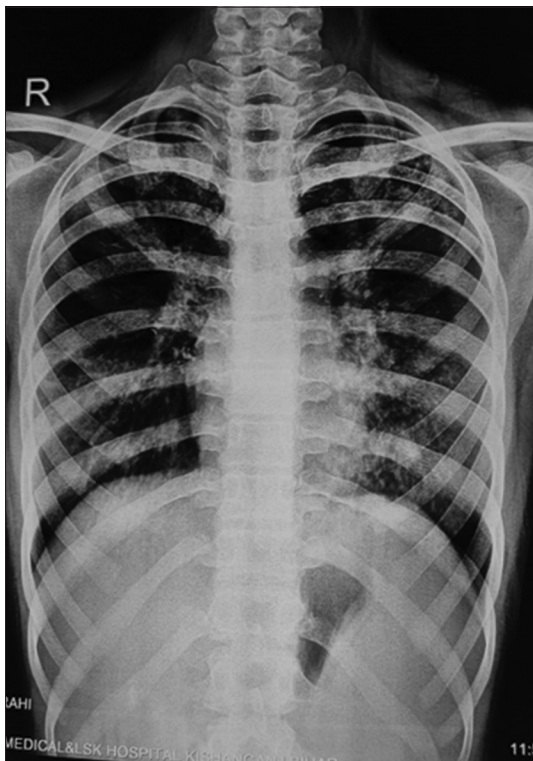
Military shadows in chest X-ray (posterior-anterior view) in a girl with MIS-C associated miliary tuberculosis^[27]
